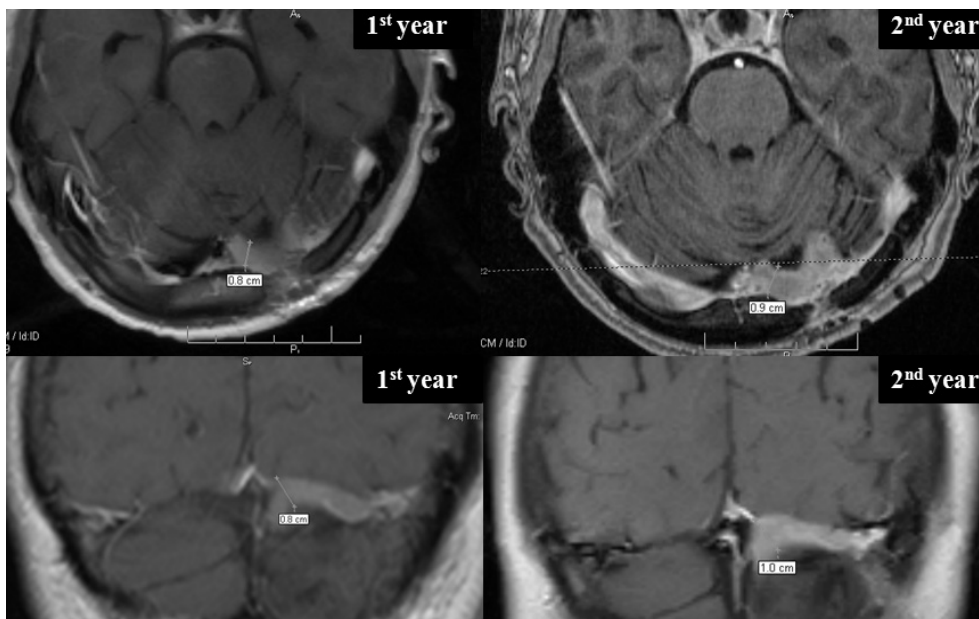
(Case 2) T1-weighted images with contrast showing local recurrence of a left transverse sinus meningioma at 2 years follow-up
